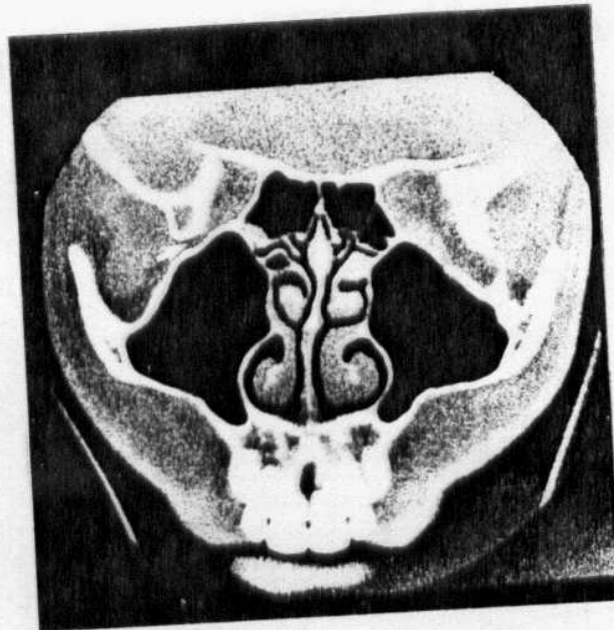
Coronal CT scan. More posterior scan clearly shows antral walls and nasal cavity structures. Inferior orbital fissure is also seen (arrow).
